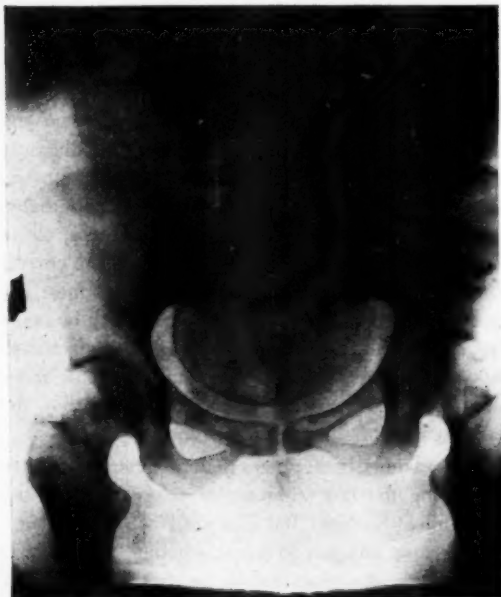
This is an x-ray film of the patient (Case 1) taken December 23, 1924. It shows a perfectly normal pelvis, an average sized baby, with sufficient room for the presenting part to pass without difficulty.
